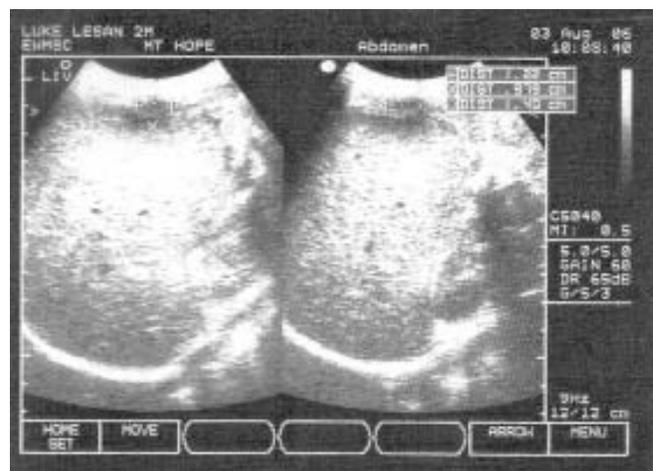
Four months after initial presentation, there is almost complete sonographic resolution of the superior subcapsular collection.
